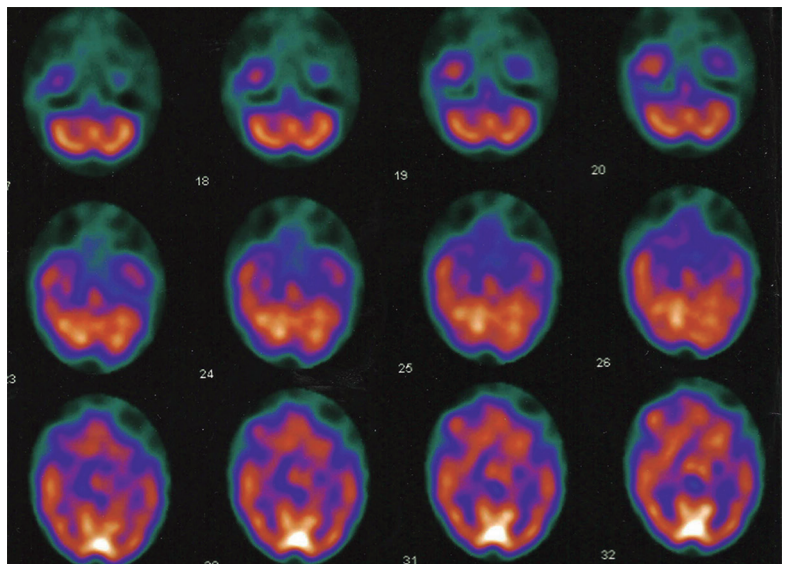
Brain SPECT (axial cuts) showing moderate asymmetric hypoperfusion in temporal lobes (L > R).
